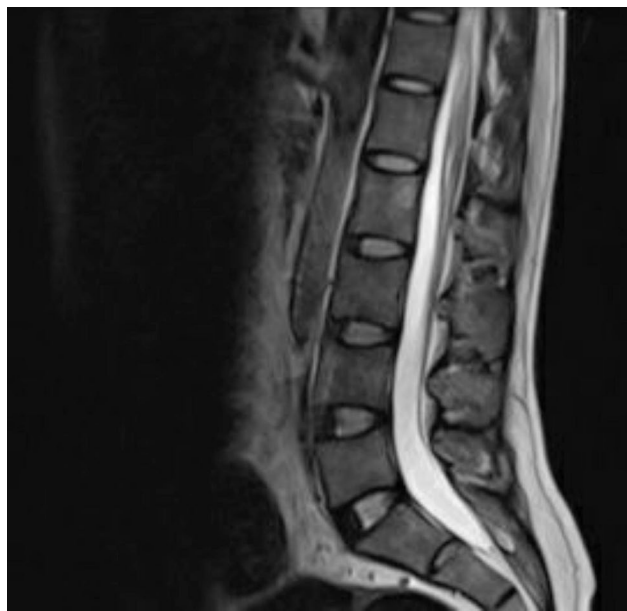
Mid sagittal T2 weighted image of lumbosacral spine MRI showing normal vertebral height, inter-vertebral disc, cord, nerve roots as well as normal intra and extra dural spaces
